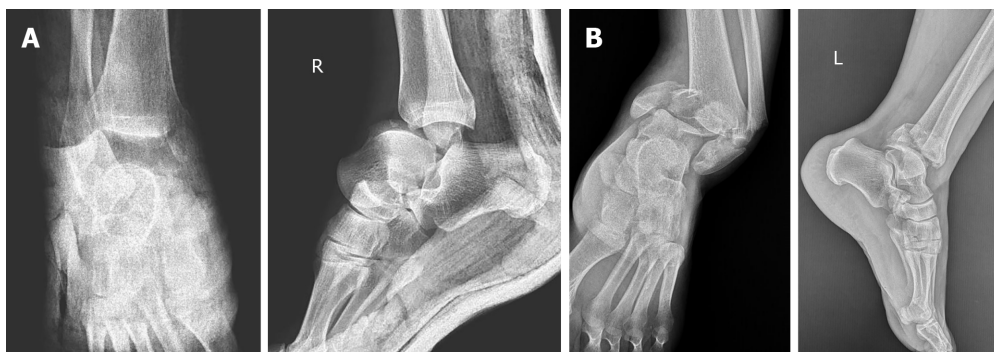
Anteroposterior and lateral ankle radiographs of the right ankle (A) showing anterolateral total talus dislocation accompanied by a fracture of the medial malleolus and pilon fracture of the left ankle (B).
